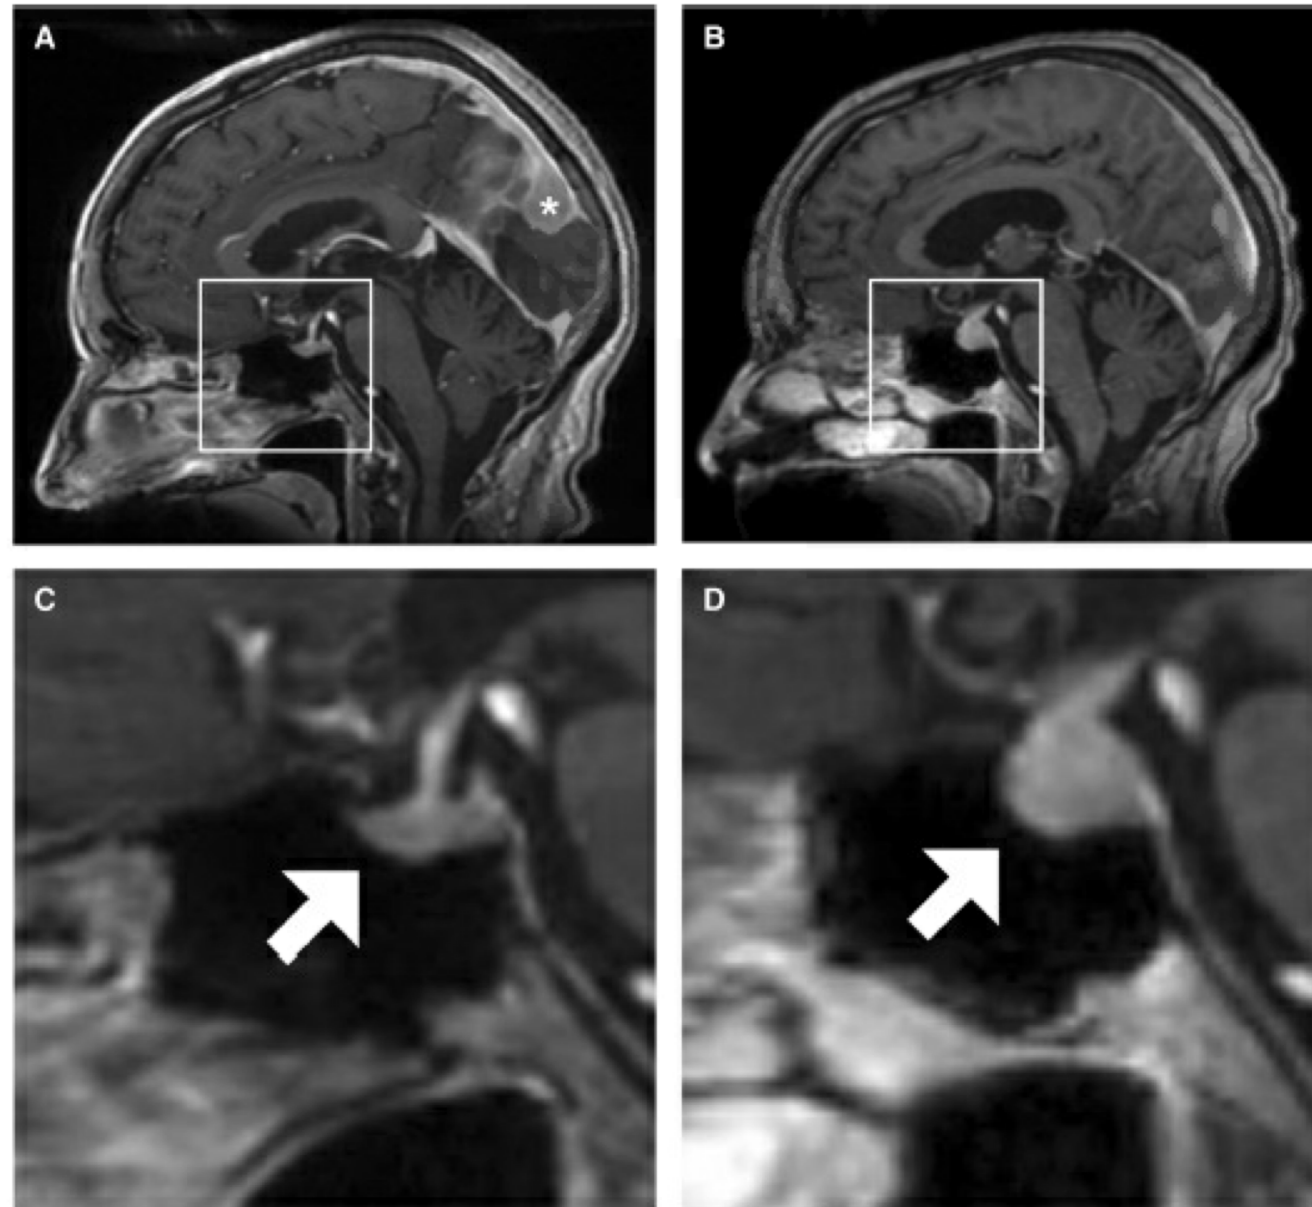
Sagittal views of the patient's brain on MRI. A Before ipilimumab and nivolumab initiation. The patient had a preexisting parafalcine meningioma (asterisk). B Five months after ipilimumab and nivolumab initiation. C Inset of panel A, with a normal-sized pituitary gland (arrow) and pituitary stalk. D Inset of panel B, with diffuse enlargement of the pituitary gland (arrow) and thickening of the pituitary stalk.
